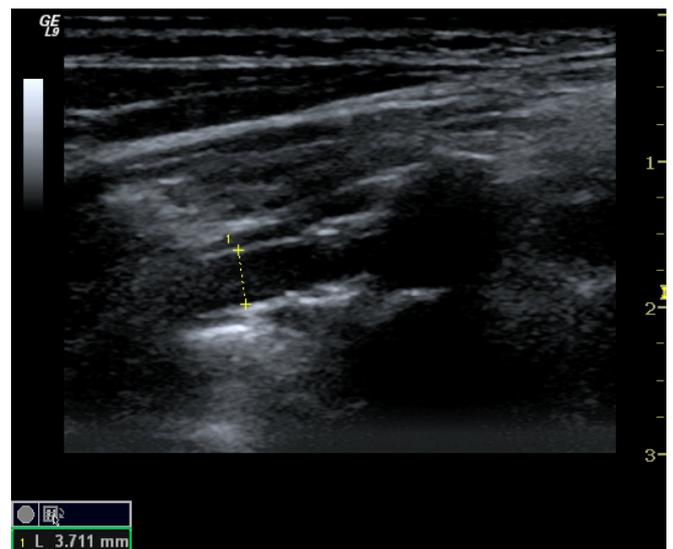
Gray-scale ultrasonographic imaging of left VA between fifth and sixth cervical vertebrae.
